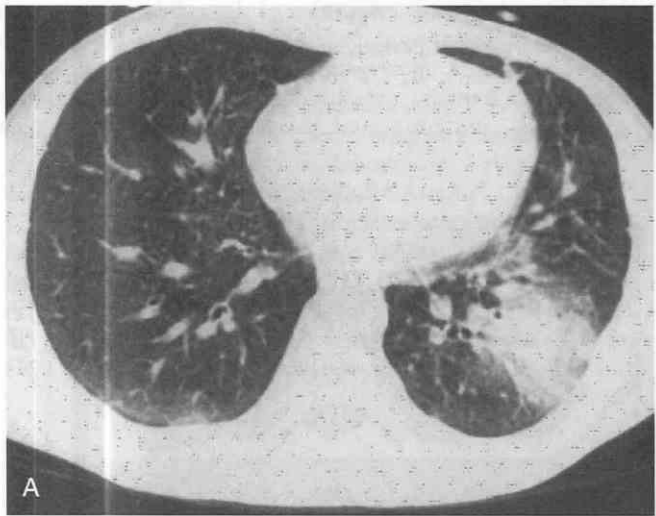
CT pattern of progression and resolution of invasive pulmonary aspergillosis. *A*, Early infection in leukemic patient with pancytopenia from chemotherapy. CT halo. *B*, After the white blood cell count has returned to normal, the lesion undergoes cavitation and air-crescent formation. *C*, With further healing, a residual thin-walled cyst and linear scar to the pleura remain. (A-C, From Kuhlman JE, Fishman EK, Burch PA, et al: CT of invasive pulmonary aspergillosis. *AJR Am J Roentgenol* 150:1015-1020, 1988.)
